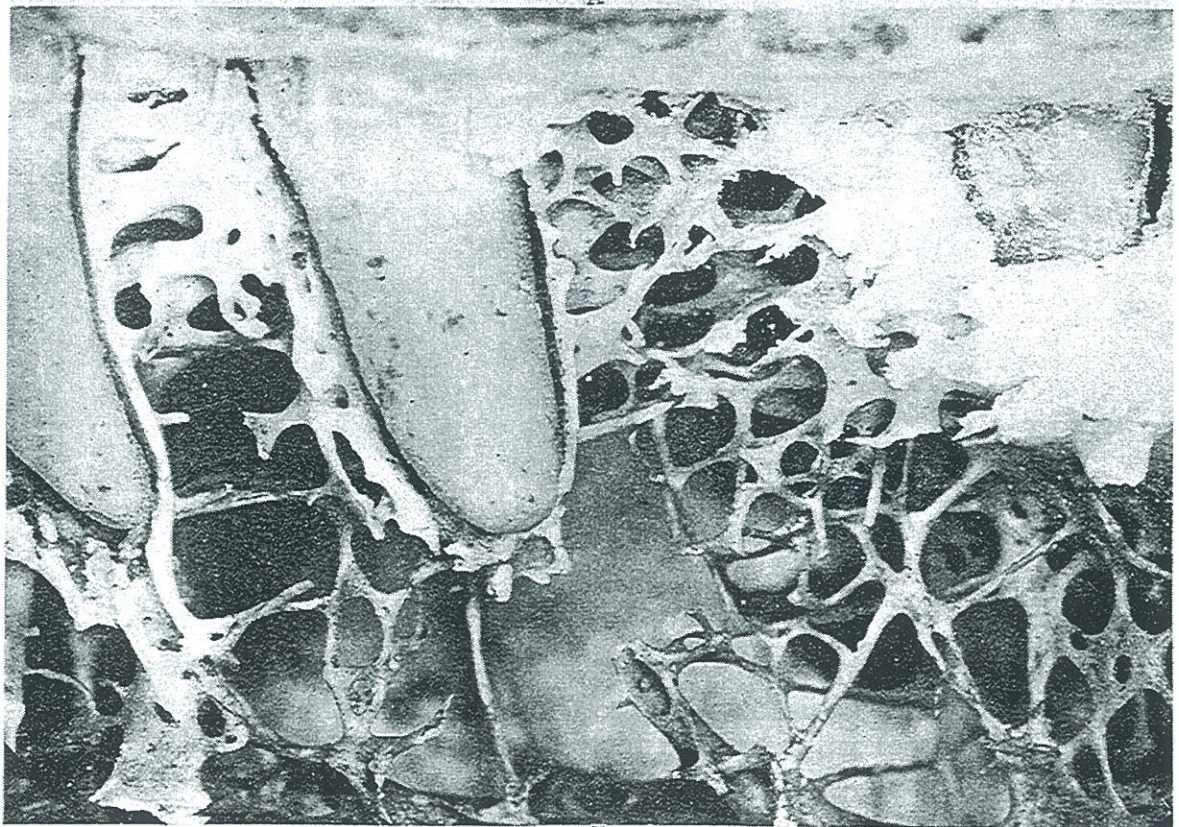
A, THE ROENTGENOGRAPHIC APPEARANCE OF THE DISSECTIONS IN B AND C. NOTE POCKET BETWEEN SECOND AND THIRD MOLARS AND ADJOINING RADIO-PACITY. B AND C SHOW THE ARRANGEMENT OF THE CALCIFIED STRUCTURES.
